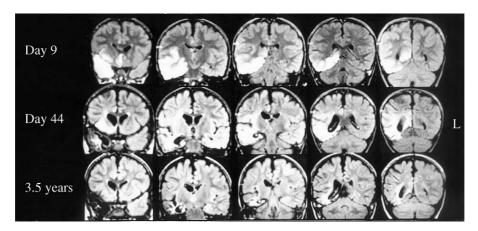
Cerebral MRI performed at 1.5 T. Upper row: cerebral MRI performed on day 9 of the first HSE episode. Coronal fluid attenuated inversion recovery (FLAIR) MRI showing diffuse hyperintensity of the right temporal lobe, the insular cortex and the inferior frontal lobe together with focal cortical and subcortical hypointensity related to hemorrhage or cortical laminar necrosis (recovery time: 6000, echo time: 150, inversion time: 2000). Middle row: cerebral MRI performed on day 44, 12 days after the beginning of the secondary acute neurological deterioration. Coronal FLAIR MRI showing severe increased signal in the white matter of the right temporal lobe and the right subcortical region. Necrosis and atrophy of the cortical region involved in the initial episode can also be observed (recovery time: 5865, echo time: 140, inversion time: 2000). Lower row: cerebral MRI performed 3.5 years after the first episode of HSE. Coronal FLAIR MRI showing severe atrophy of the right temporal lobe and the right subcortical region (recovery time: 6500, echo time: 150, inversion time: 2100). An incomplete regression of the white matter lesions can be observed.
